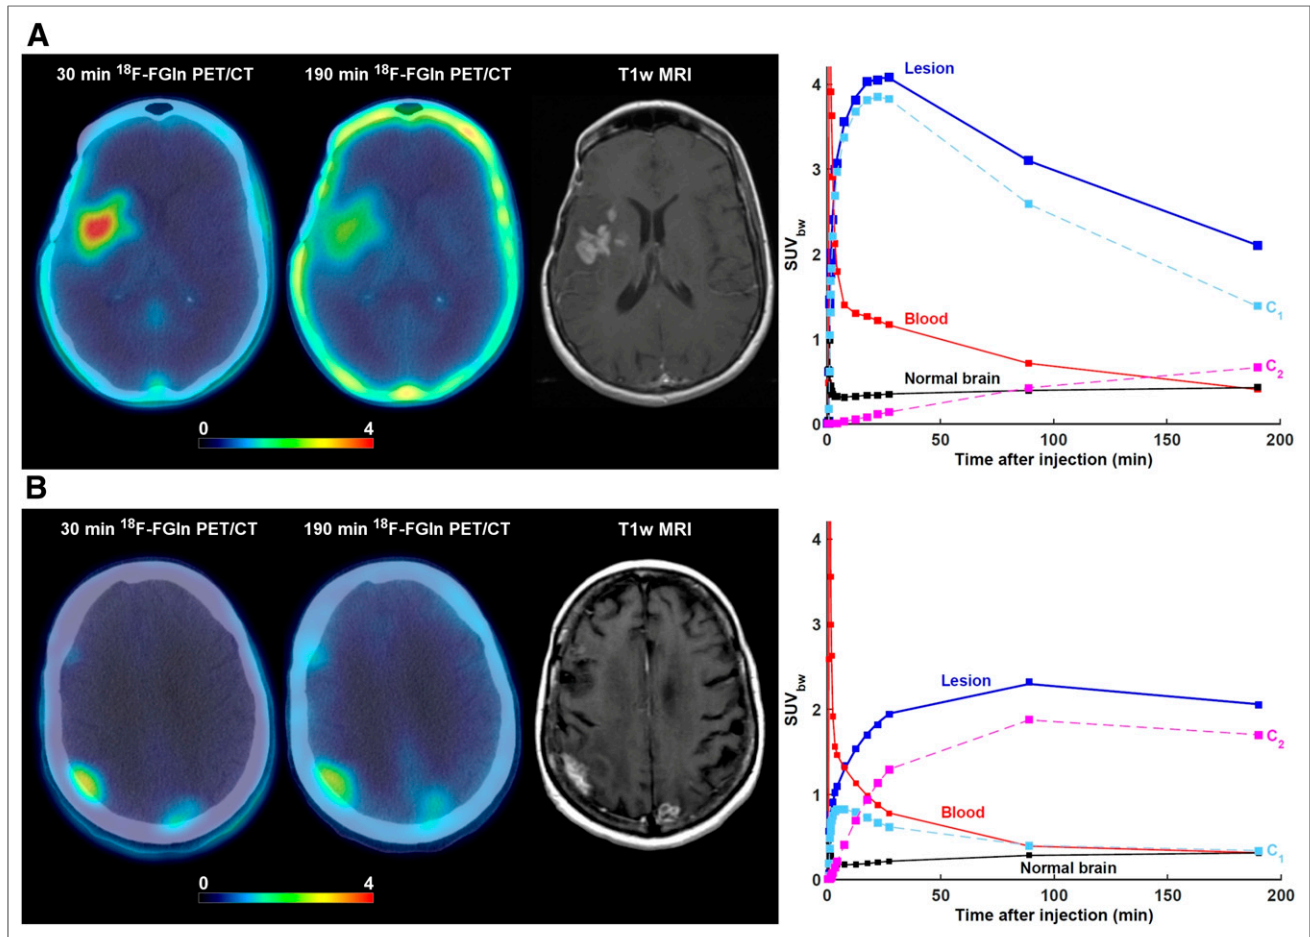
Lesions from 2 patients exhibiting different ^{18}F -FGln pharmacokinetics despite having very similar SUV corrected by body weight (SUV_{bw}) as measured at 190 min after injection. In both cases, axial view of last dynamic PET frame (5-min acquisition time, 25–30 min after injection) and last imaging frame (~190 min after injection), fused with corresponding CT, is displayed. Gadolinium-enhanced T1-weighted MRI is included for comparison. Three time–activity curves are shown: for whole lesion; image-derived input function scaled by whole-blood activity concentration as measured from blood samples, patient-specific plasma fraction, and population-based metabolite fraction; and normal brain tissue. Contributions to total PET signal for tumor time–activity curves are shown for first compartment (C_1) and second compartment (C_2). (A) 52-year-old woman with confirmed diagnosis of astrocytoma. ^{18}F -FGln PET/CT shows 2 cm^3 lesion in right frontotemporal region. Mean intratumor K_1 , k_2 , k_3 , k_4 , and V_T were 0.28 $\text{mL}/\text{min}/\text{g}$, 0.08 min^{-1} , 0.002 min^{-1} , 0.001 min^{-1} , and 3.9 mL/cm^3 , respectively. Corresponding values for normal brain tissue were 0.02 $\text{mL}/\text{min}/\text{g}$, 0.09 min^{-1} , 0.001 min^{-1} , 0.001 min^{-1} , and 0.5 mL/cm^3 , respectively. SUV_{bw} at 30, 90, and 190 min was 4.0, 3.1, and 2.1, respectively. At these 3 time points, signal from second compartment contributed 3%, 14%, and 32% of total PET activity concentration. (B) 70-year-old woman with confirmed diagnosis of non-small cell lung cancer that metastasized to brain. PET image shows metastatic lesion in right parietal region. Mean intratumor K_1 , k_2 , k_3 , k_4 , and V_T were 0.13 $\text{mL}/\text{min}/\text{g}$, 0.13 min^{-1} , 0.09 min^{-1} , 0.02 min^{-1} , and 5.1 mL/cm^3 , respectively. Corresponding values for normal brain tissue were 0.01 $\text{mL}/\text{min}/\text{g}$, 0.05 min^{-1} , 0.04 min^{-1} , 0.004 min^{-1} , and 0.7 mL/cm^3 , respectively. SUV_{bw} at 30, 90, and 190 min was 1.9, 3.1, and 2.1, respectively. At these 3 time points, signal from second compartment contributed 66%, 82%, and 83%, respectively, of total PET activity concentration.
